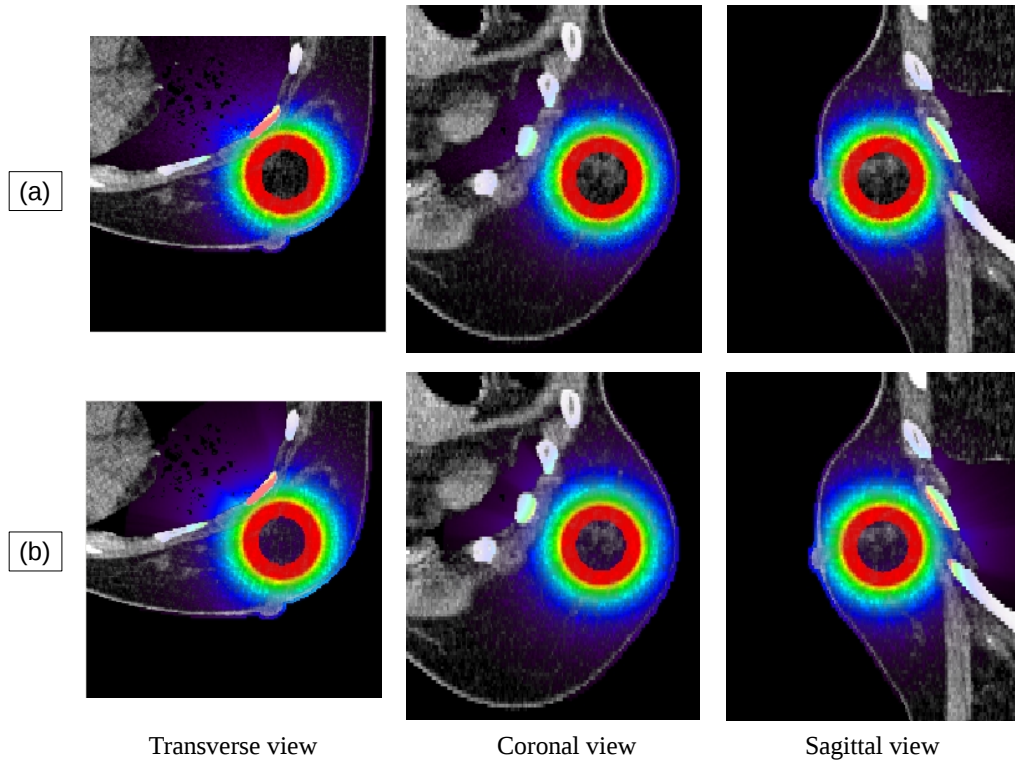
Dose distribution on a CT representing a breast conserving treatment with (a) penEasy, (b) HMC
